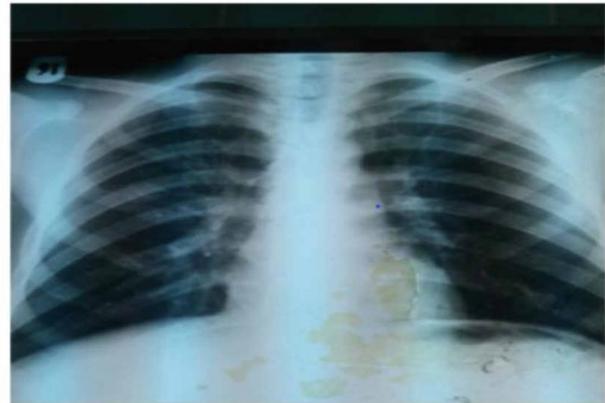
Chest radiograph shows normal chest appearance
